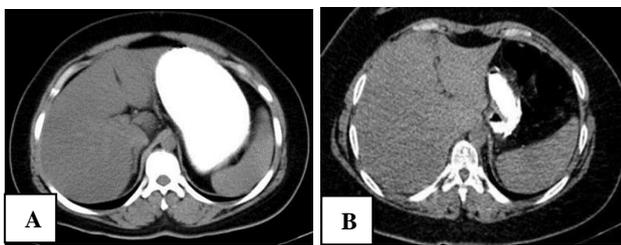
(A and B): Pre and postoperative axial CT image of distended stomach.
